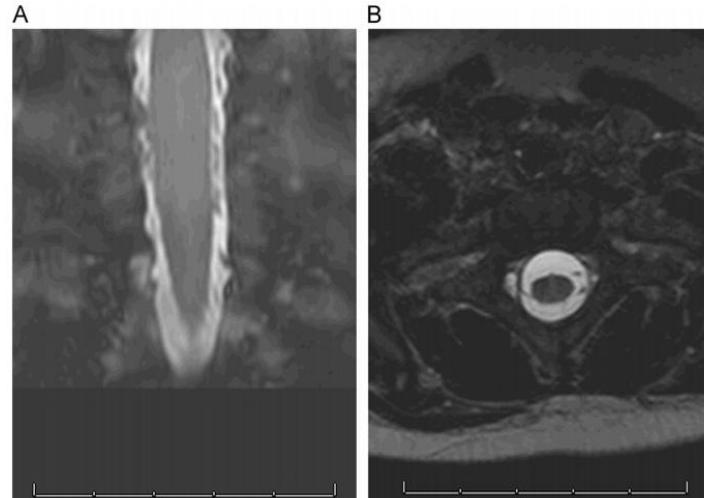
A MR image of an avulsion lesion (A) coronal (B) axial.
